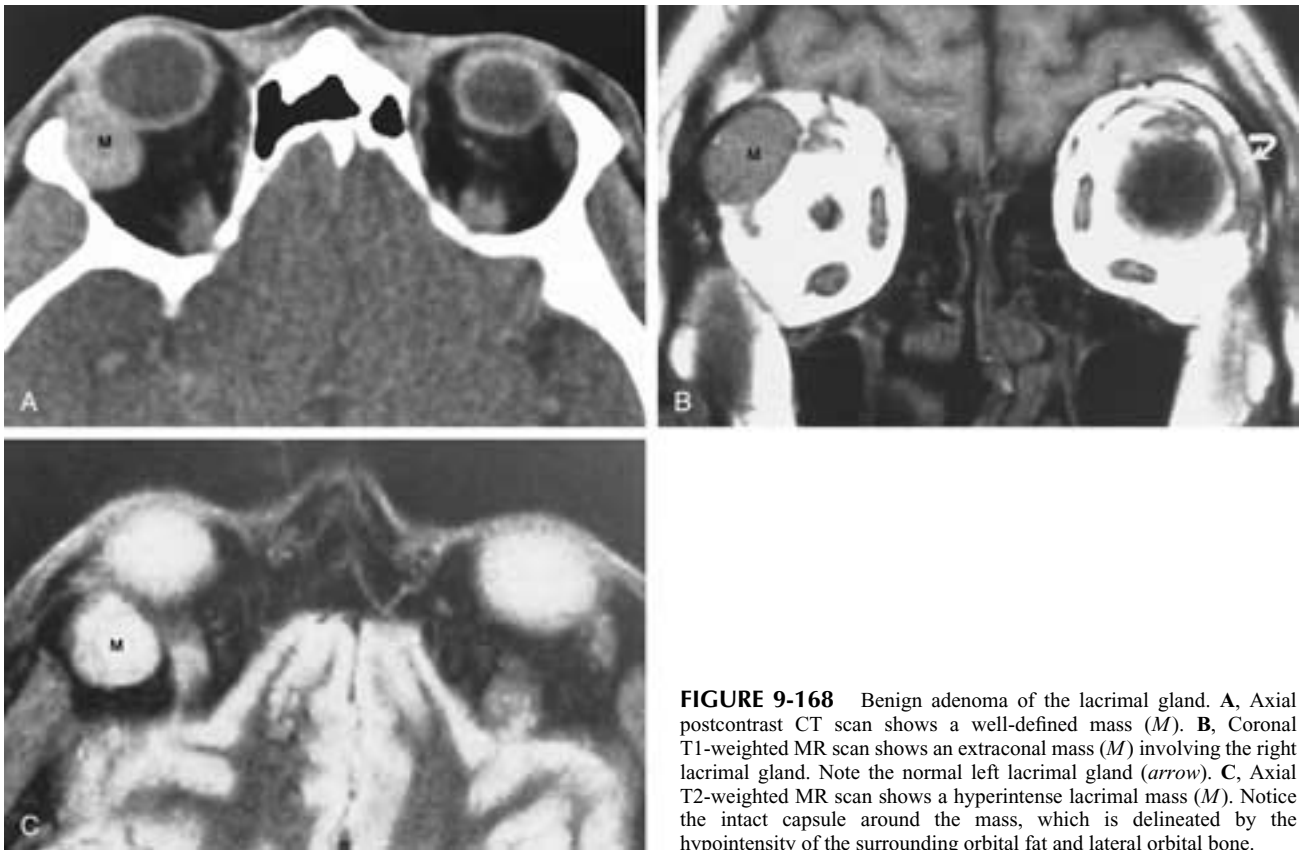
Benign adenoma of the lacrimal gland. A, Axial postcontrast CT scan shows a well-defined mass (*M*). B, Coronal T1-weighted MR scan shows an extraconal mass (*M*) involving the right lacrimal gland. Note the normal left lacrimal gland (*arrow*). C, Axial T2-weighted MR scan shows a hyperintense lacrimal mass (*M*). Notice the intact capsule around the mass, which is delineated by the hypointensity of the surrounding orbital fat and lateral orbital bone.
